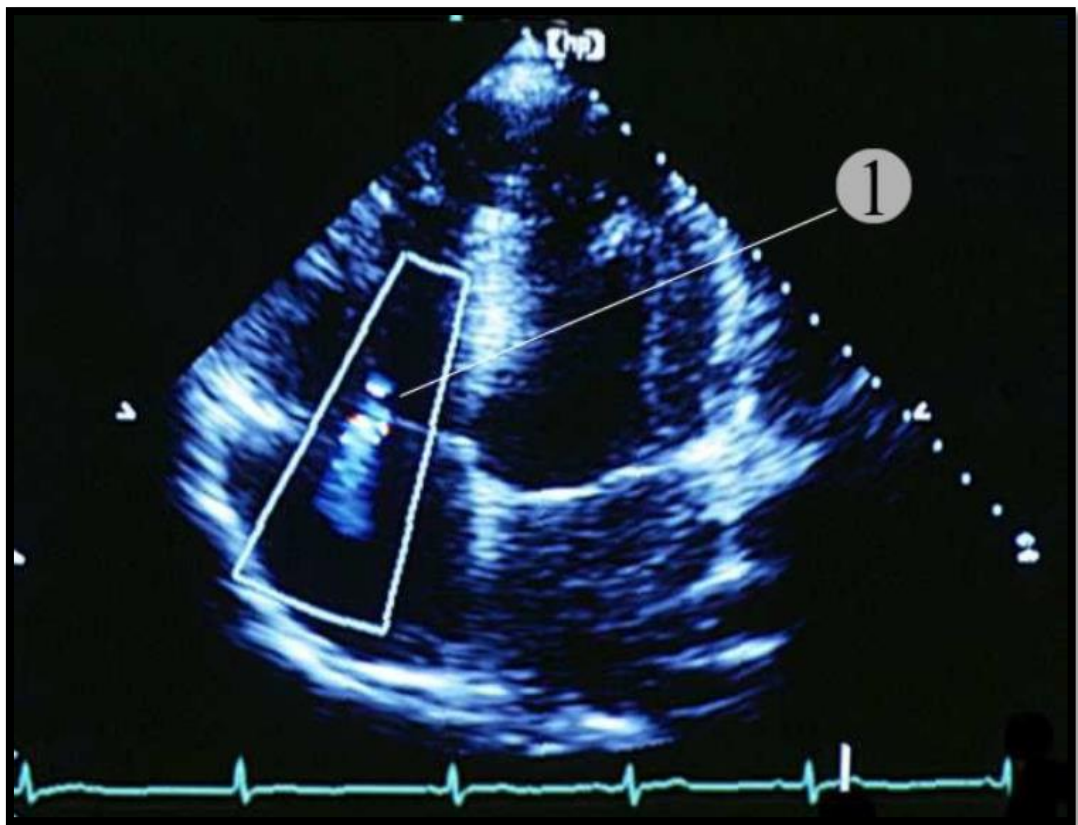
Tricuspid regurgitation (1) visualised in colour Doppler mode from an apical 4-chamber view.
